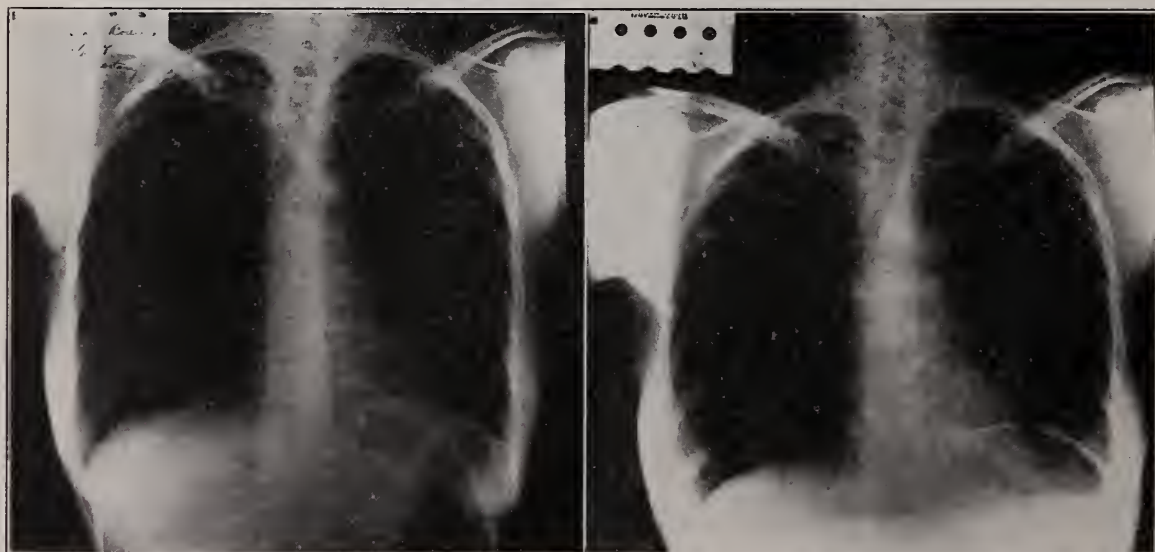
Roentgenograms of chest of Mrs. R. Taken before and after paralysis of the left diaphragm. The relaxation and elevation of this structure has done away with the pull on the adhesions between it and the lung.
